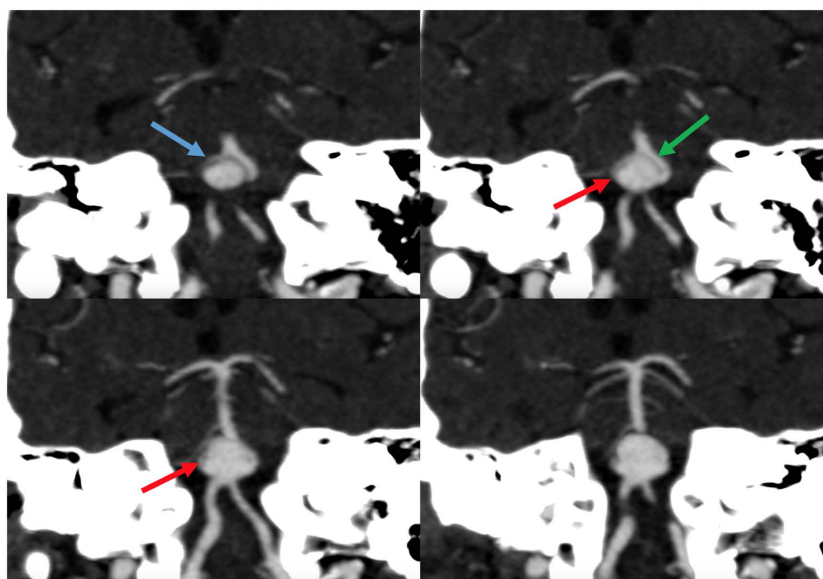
Cerebral CT angiography. Oblique coronal MIP reconstructions (Maximum Intensity Projection) allow visualization of the asymmetric fenestration of the basilar artery at its origin, with a right branch (blue arrow) and a dominant left branch (green arrow), surrounding the aneurysmal sac (red arrows).
